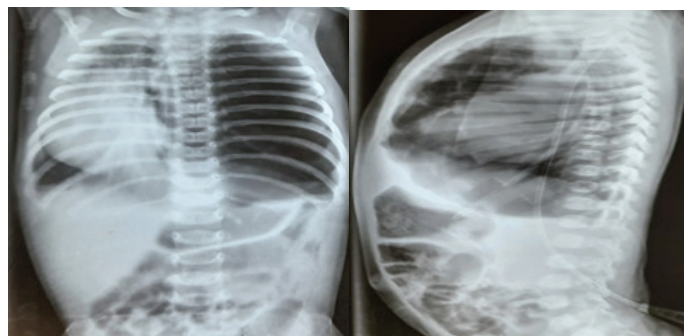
Initial chest radiograph showing large hyperlucency in left hemithorax, crossing the midline and extending to involve partly right hemithorax. The mediastinum including the trachea and cardia has been shifted to the right.
